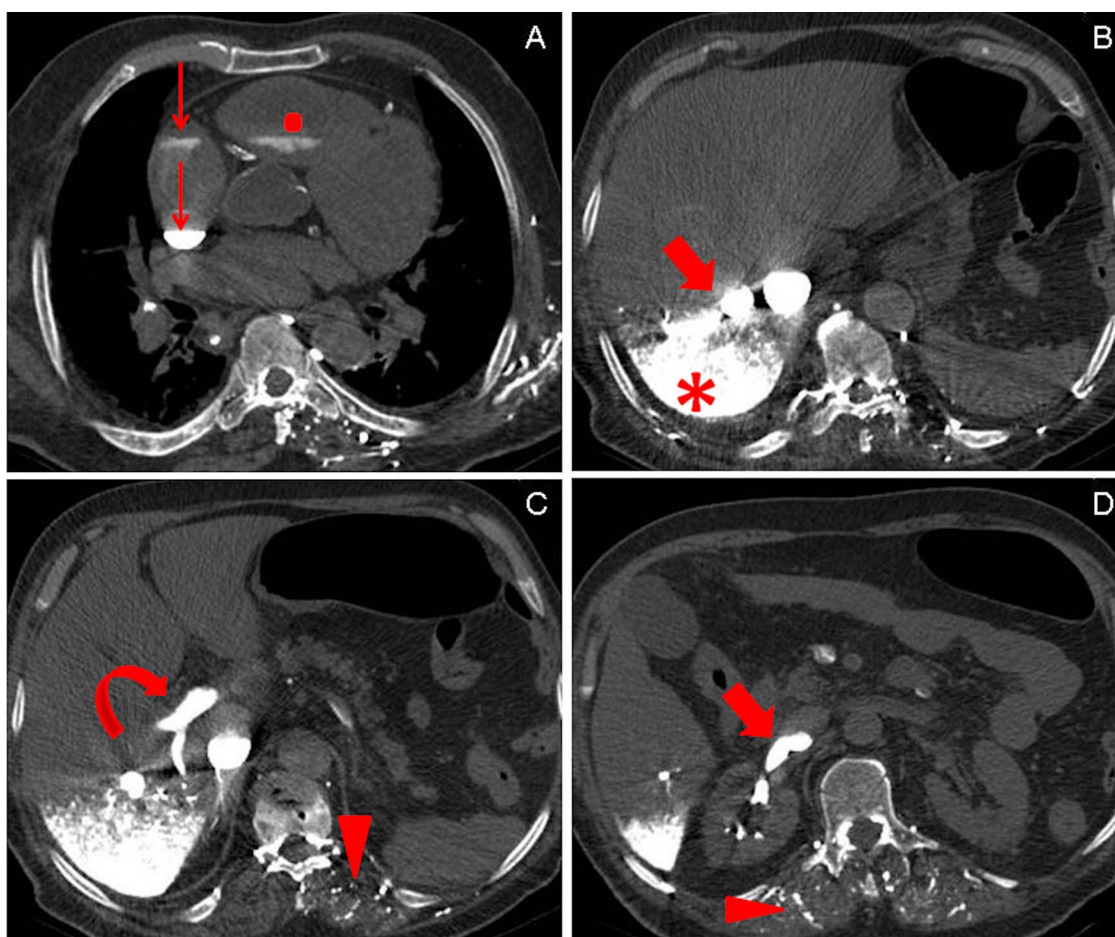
Axial CT images after contrast administration show the typical described findings of cardiac arrest.
